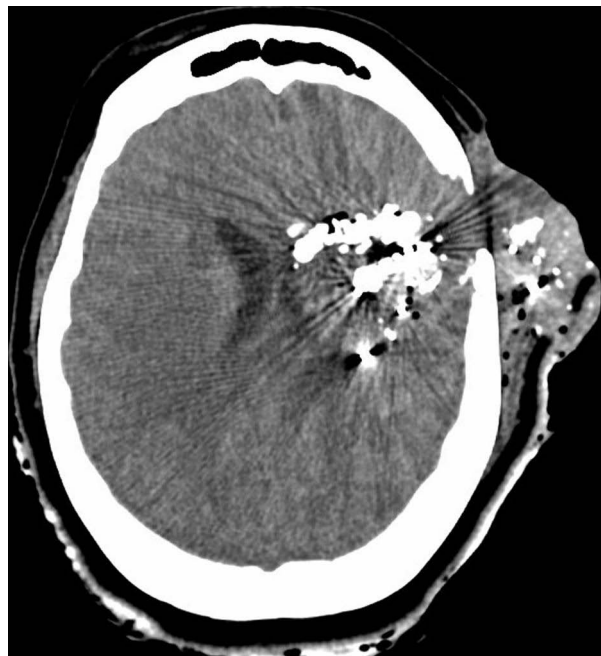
Axial view of the CT showing left-sided extracranial cerebral herniation and retained bullet fragments.
